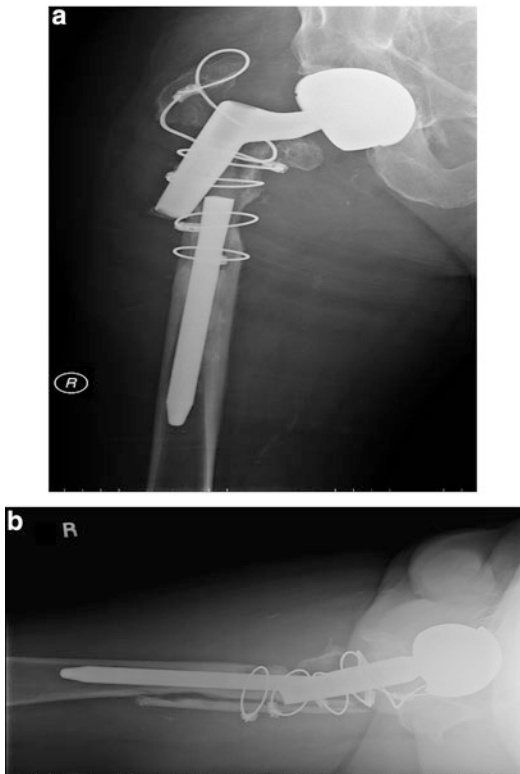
AP and lateral radiographs of the right hip and femur demonstrating a fractured modular, bi-body stem with associated periprosthetic femur fracture. Note the severe proximal femoral bone loss
